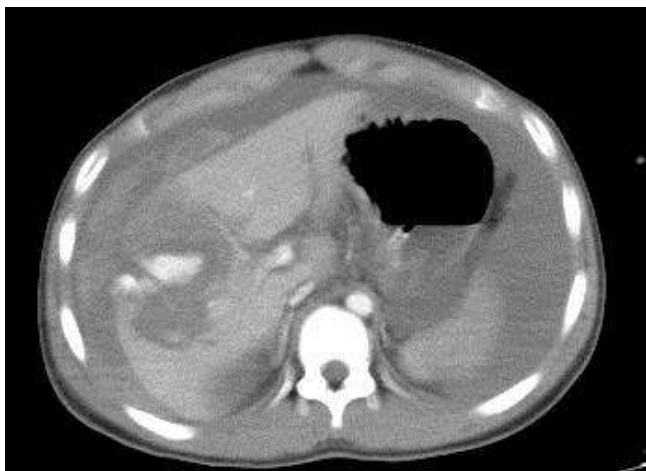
Axial Contrast enhanced CT of a 22yr old young male who had high collision motor vehicle injury shows Grade V liver injury with active contrast extravasation and massive hemoperitoneum. FLAT IVC is noted in the patient indicating hypovolemia. Intraoperatively the patient was found to have Portal vein injury.
